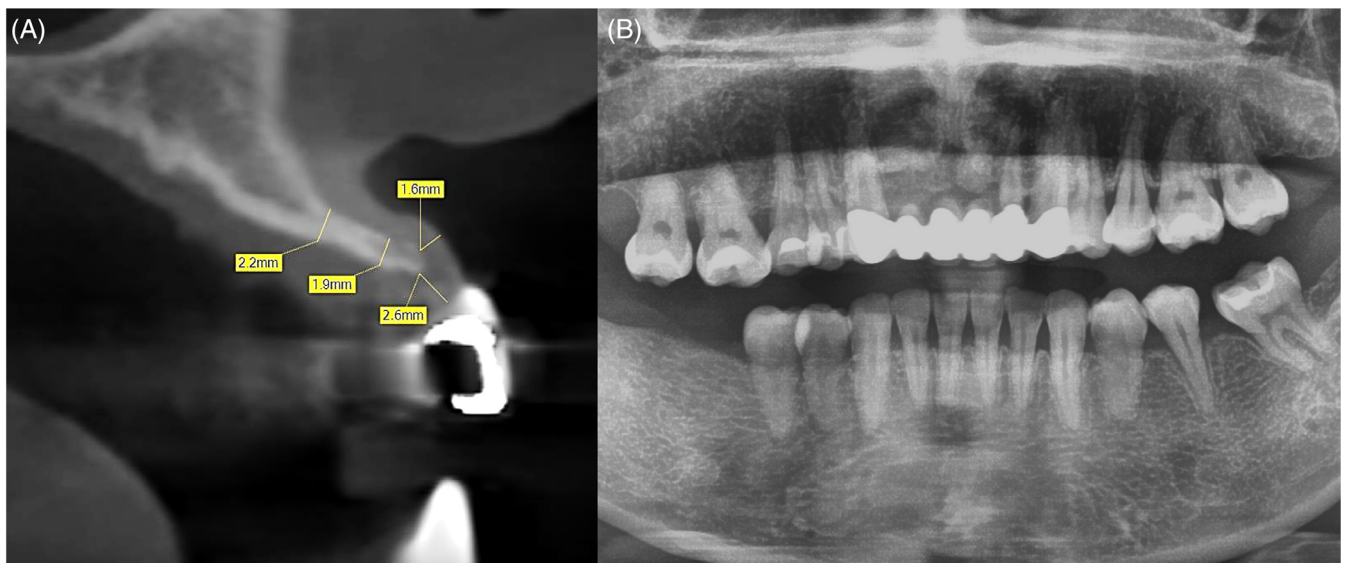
(A) and (B) Preoperative panorex radiograph and CBCT of site #8 show severe alveolar ridge atrophy
